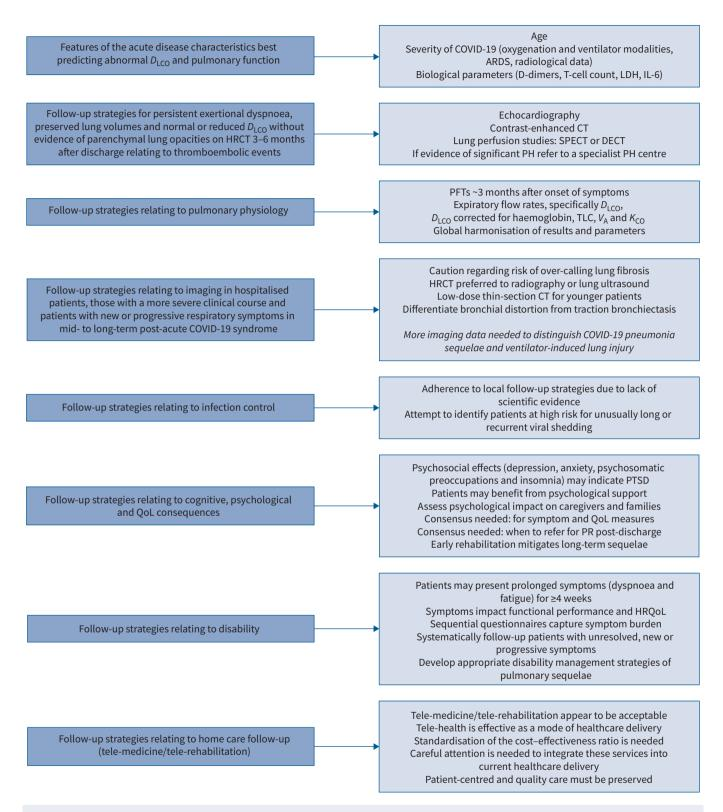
Current practice of the Task Force members on their management of patients with long COVID-19, 1–6 months post-acute COVID-19 infection (based on the eight clinical priorities and questions listed in table 1). This figure describes the current practice of how the members of the Task Force treat patients with COVID-19 and is not intended as a recommendation for clinical practice. D_{LCO} : diffusing capacity of the lung for carbon monoxide; ARDS: acute respiratory distress syndrome; LDH: lactate dehydrogenase; IL: interleukin; (HR)CT: (high-resolution) computed tomography; SPECT: single-photon emission computed tomography; DECT: dual-energy computed tomography; PH: pulmonary hypertension; PFT: pulmonary function test; V_A : alveolar volume; K_{CO} : transfer coefficient of the lung for carbon monoxide; PTSD: post-traumatic stress disorder; (HR)QoL: (health-related) quality of life; PR: pulmonary rehabilitation.
